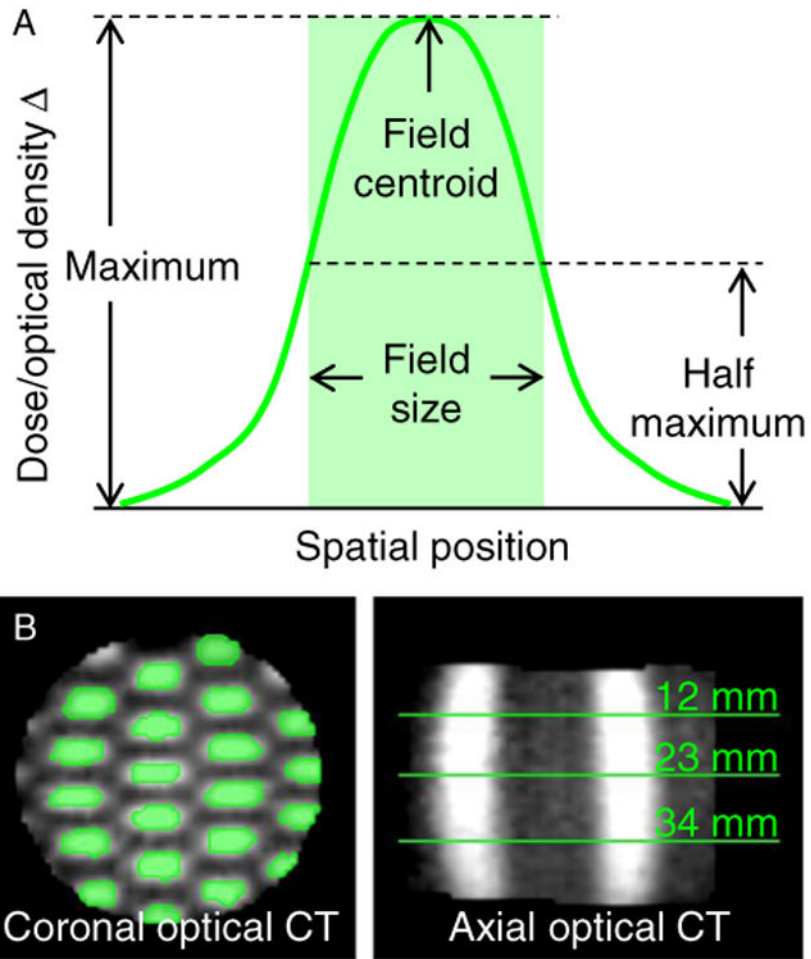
(A) Each deformed field was autosegmented at half of its maximum intensity value, and the field's length and width were measured. (B) The segmented fields (green regions in the coronal view) were analyzed at 3 cross-section depths from the incident beams (green lines in the axial view). CT, computed tomography. (Color version available online at www.practicalradonc.org).
